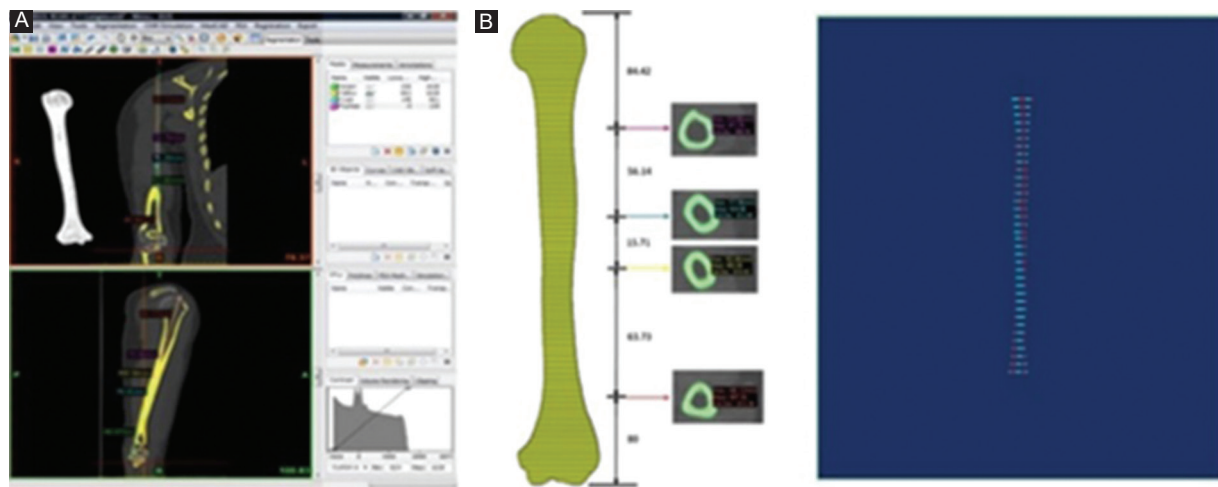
A: CT sections obtained with the software. B: Creation of polylines as a guide for CT scans cleaning and measurement. Software: Mimics, 3-matic (Materialise Inc., Leuven, Belgium).
